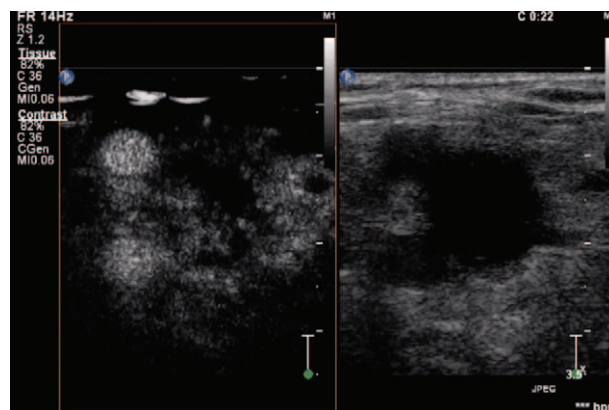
Contrast-enhanced ultrasonography (intravenous injection of Sonovue, 1.0 mL) showing that the microbubble quickly entered the mass in the arterial phase.
